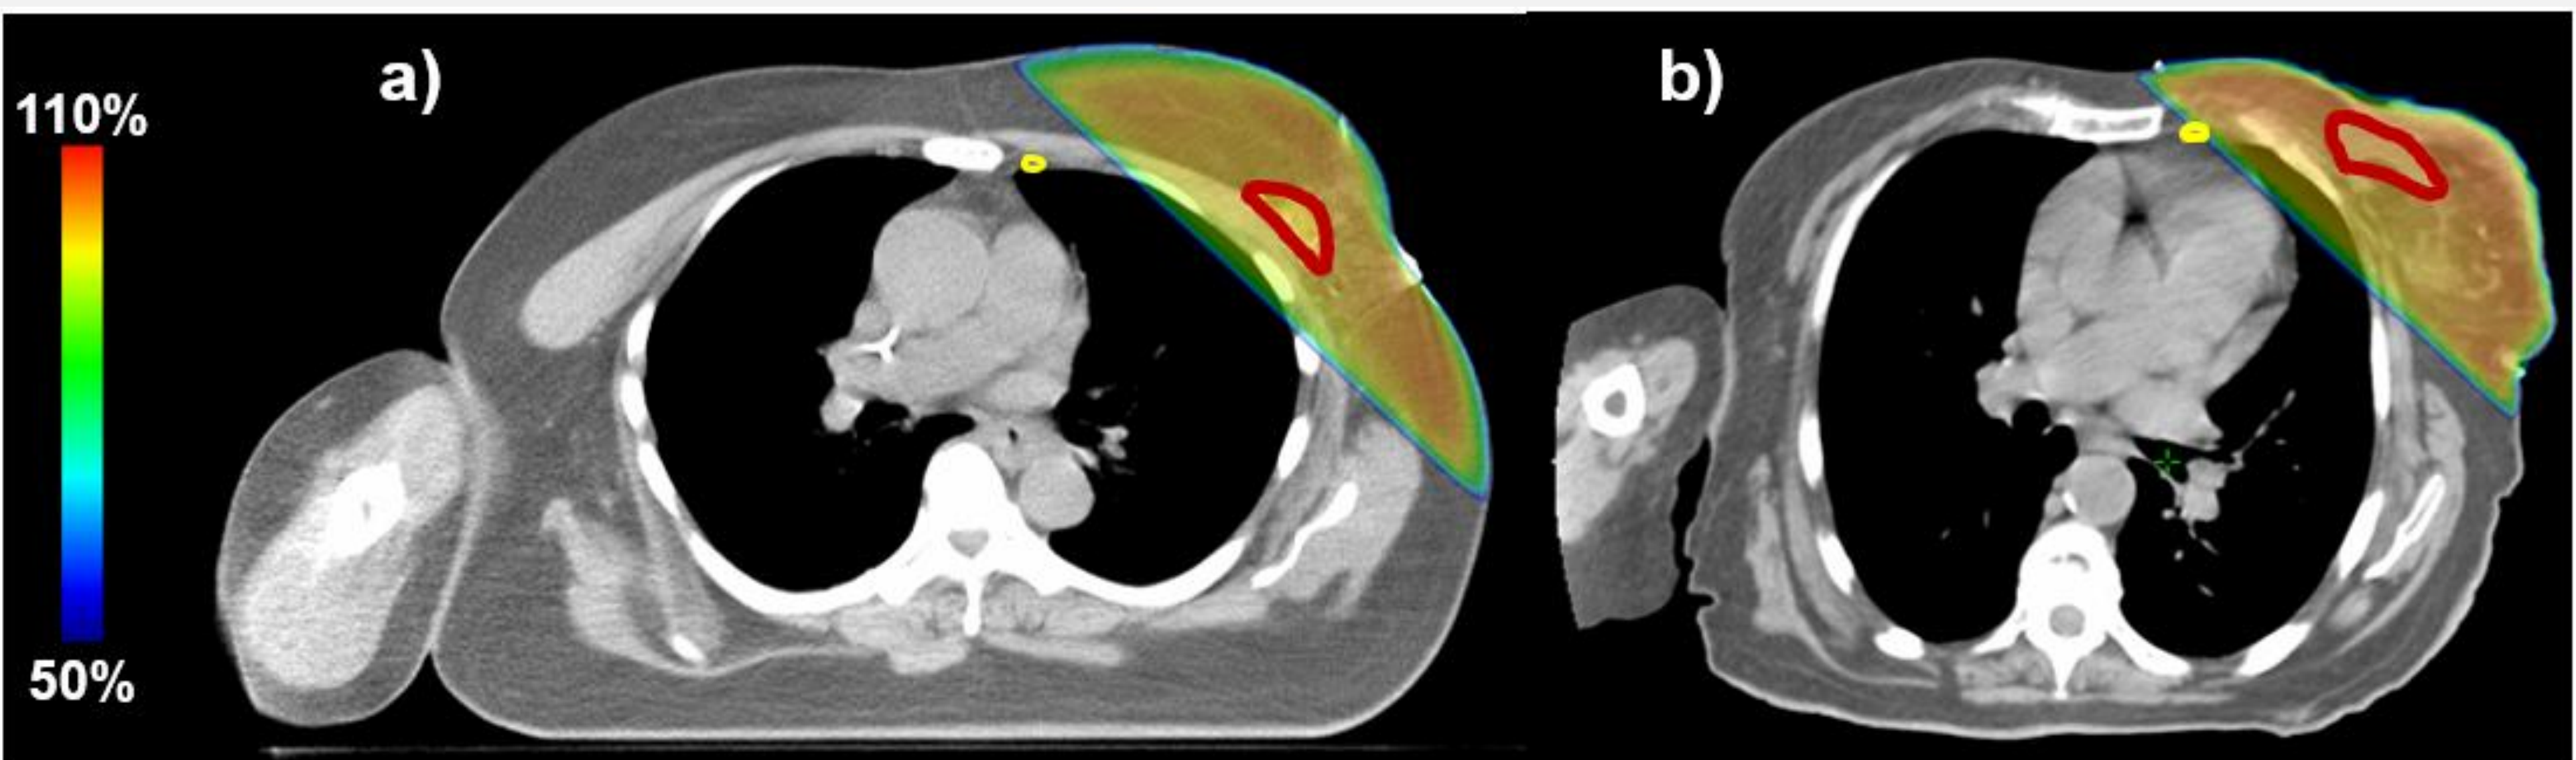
Axial CT images and radiotherapy plans for breast cancer patients where the IMLNs receive (a) a low mean dose and (b) a high mean dose. The seroma is outlined in red and the IMLNs in yellow. The dose distribution is shown in colour wash (50 – 110% of the prescribed dose).
